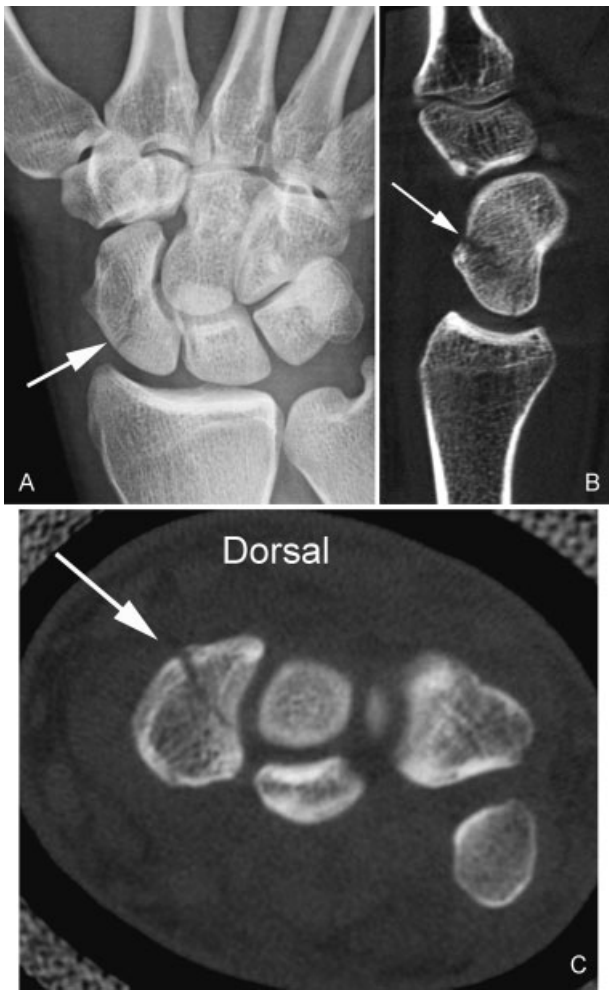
(A) Undisplaced waist fracture with proximal extension into the proximal pole (arrow). (B,C) computed tomography scan shows a proximal partial coronal fracture that starts off in the axial plane and then goes into the coronal plane (arrows) (Figure 3 B,C).
